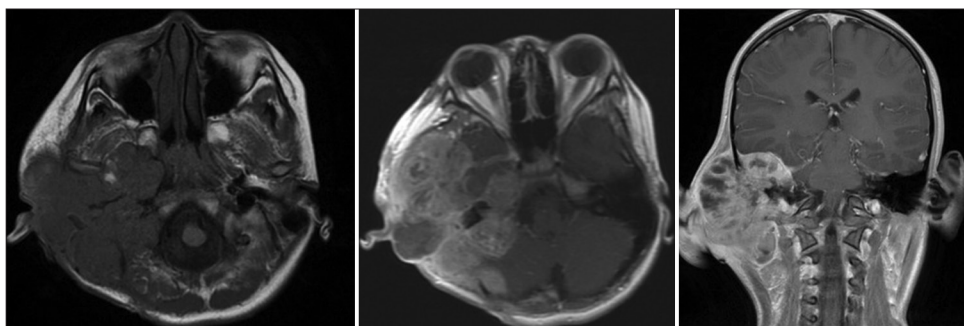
Head magnetic resonance imaging with contrast axial and coronal view, there is hyperintense on T1-weighted image, a mass was seen destroying the right mastoid, right temporal bone, and part of the sphenoid, visible intracranial extradural extension.
